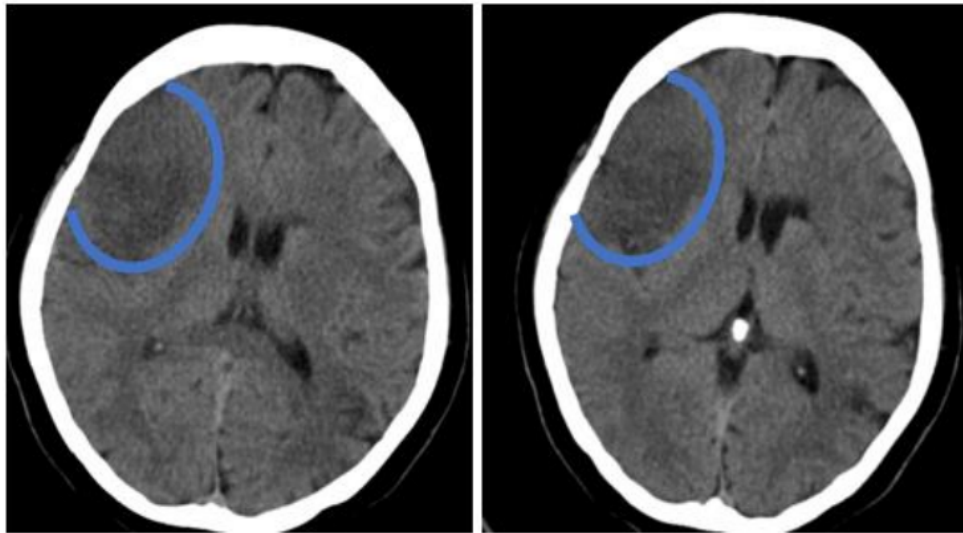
An ischemic was found in the left frontotemporal region based on the plain brain CT scan
